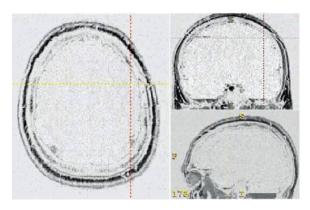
Subtraction images of two 3D MRI brain scans performed in a healthy individual. The brains in the two scans have been coregistered and subtracted resulting in complete loss of structural information in the brain. Note that the peripheral tissues are clearly seen since these were removed from one data set prior to coregistration
